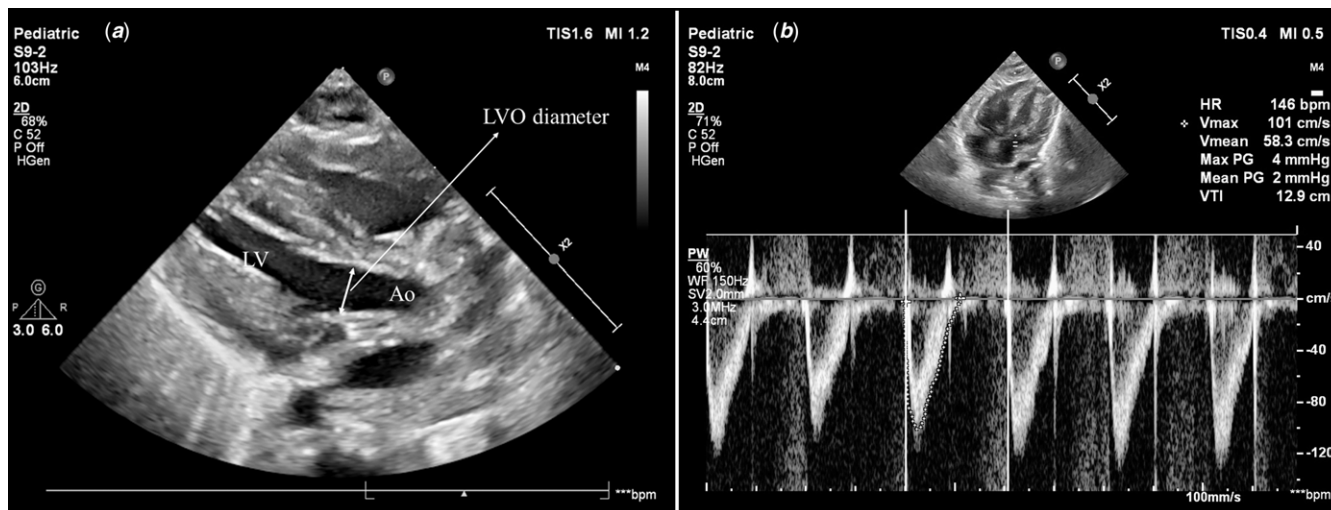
Left ventricular outflow measurement on echocardiography. (a) Left ventricular outflow diameter. (b) Left ventricular outflow velocity time integral (VTI).
